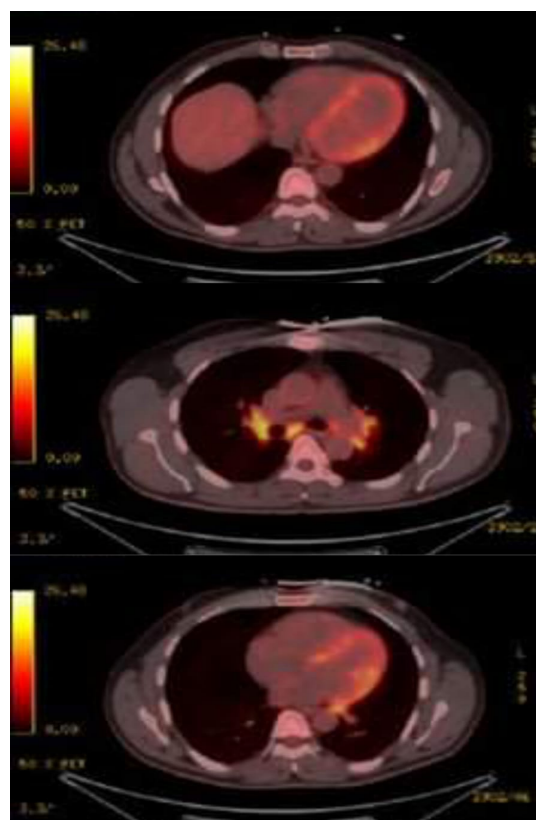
FDG-PET scan of the heart, showing curvilinear FDG uptake throughout the left ventricular (LV) myocardium including the free wall and interventricular septum, and a slightly more intense focal uptake at the interventricular septum.
